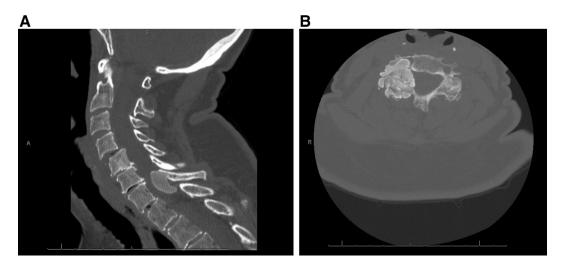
A, 2B Pre-operative Sagittal (2A) and Axial (2B) view CT images without contrast demonstrating a large, well-demarcated epidural mass with significant calcification extending from the midline of the C7 lamina, as well as subluxation of C4 on C5.
